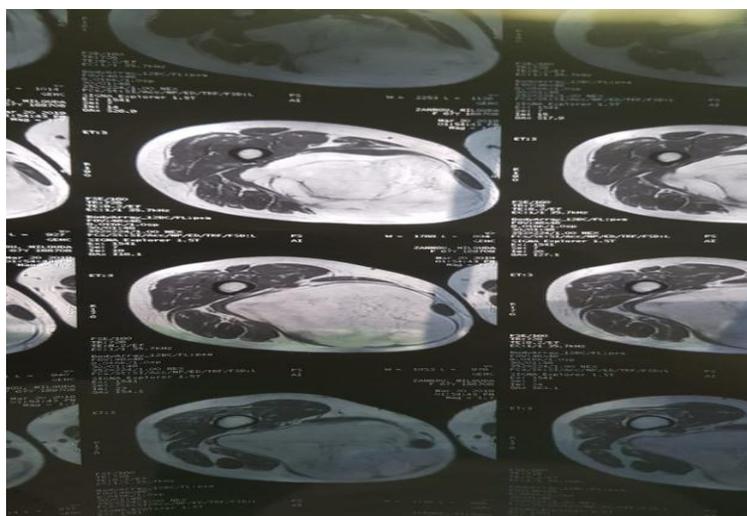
Transverse view of the tumor in MRI.
